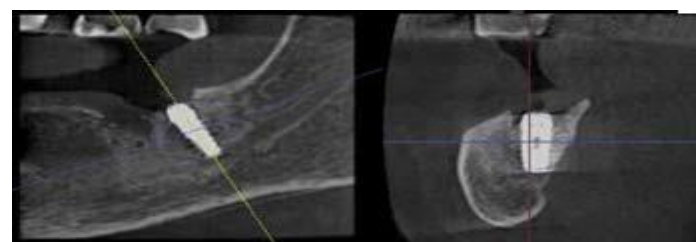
CT scan after surgery, nerve pressure with left distal implant
